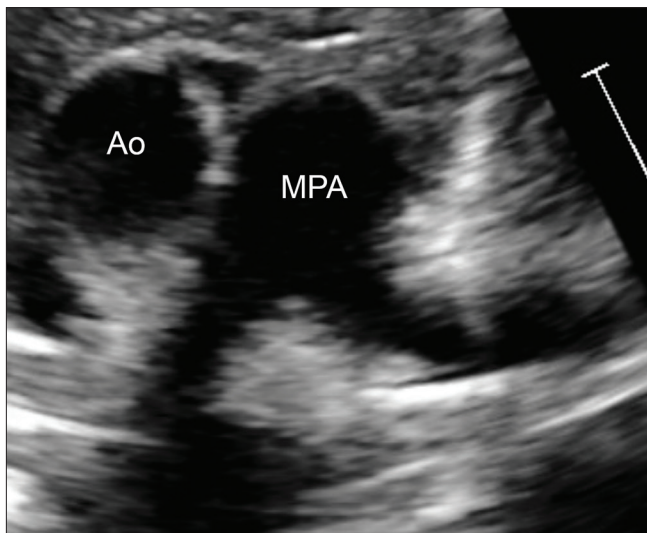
Transthoracic echocardiogram (parasternal view) showing complete resolution of pulmonary artery thrombi
